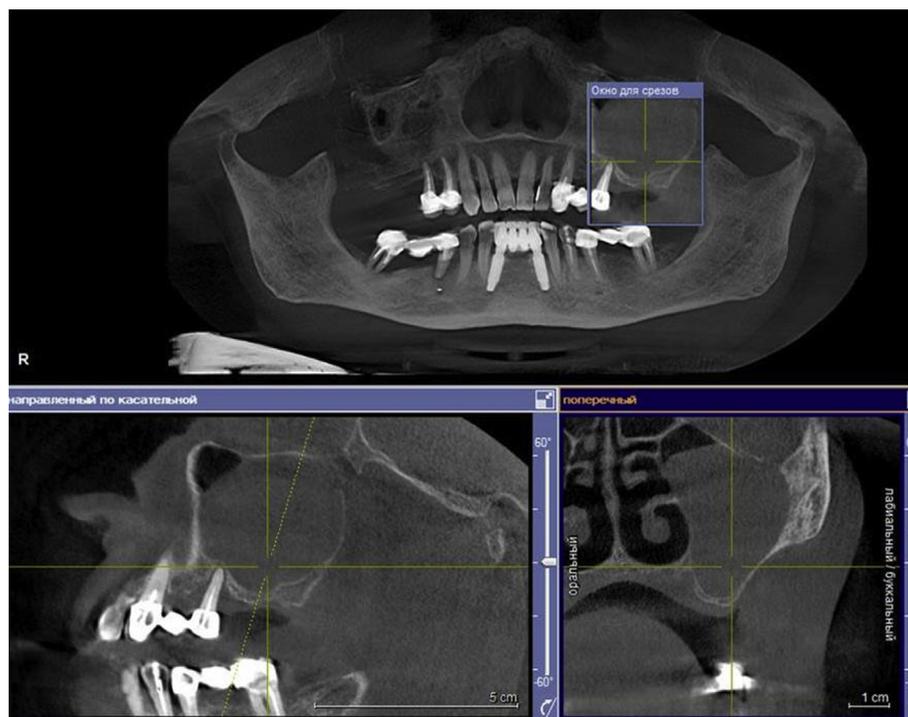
Preoperative CT scan of a patient with a large maxillary sinus pseudocyst.
